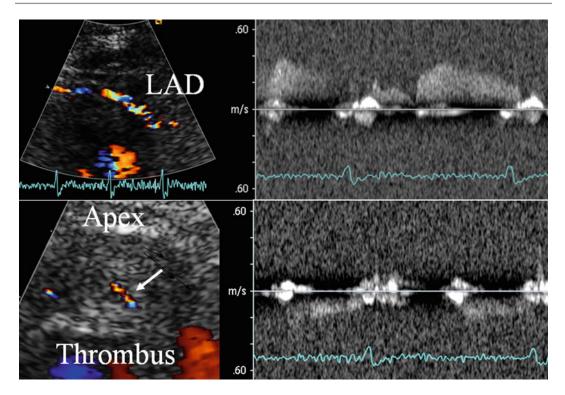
Transthoracic color-Doppler echocardiography. Vascularized apical thrombus. *Upper panel*: epicardial tract of the left anterior descending (LAD) coronary artery visualized by color-Doppler and the corresponding pulsed
